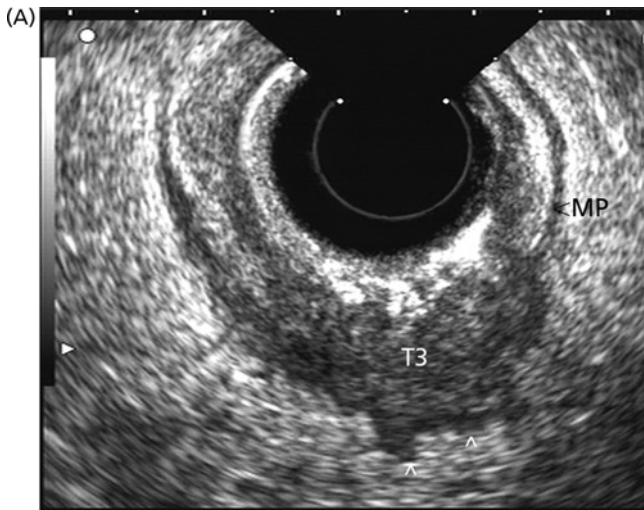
(A) Radial EUS of a T3 N1 lesion showing the primary rectal tumor penetration through the muscularis propria (MP) into perirectal fat (*arrowhead*). (B) Radial EUS of the patient in Figure 19.3A showing a 7 mm round, perirectal, hypoechoic lymph node with no flow on color Doppler with an adjoining vessel nearby with color flow.
